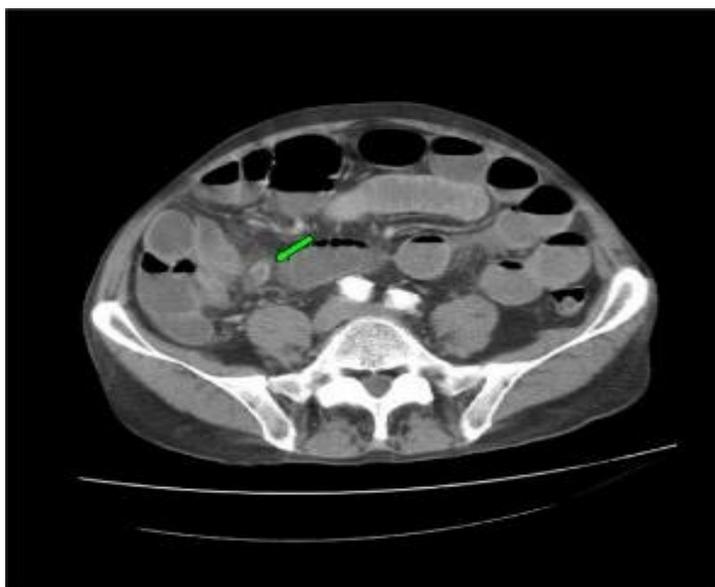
CT scan with contrast in a patient with a small bowel obstruction.
